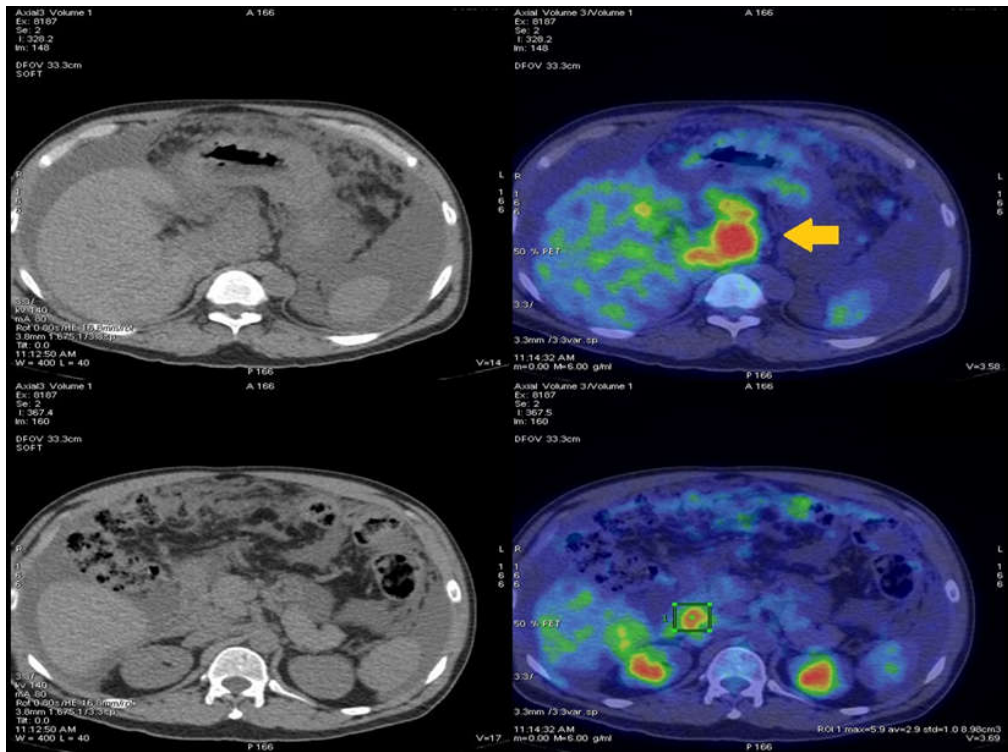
Fused axial images of FDG PET-CT showing metabolically active porta hepatic lesion (arrow) and enlarged paracaval lymph node.
